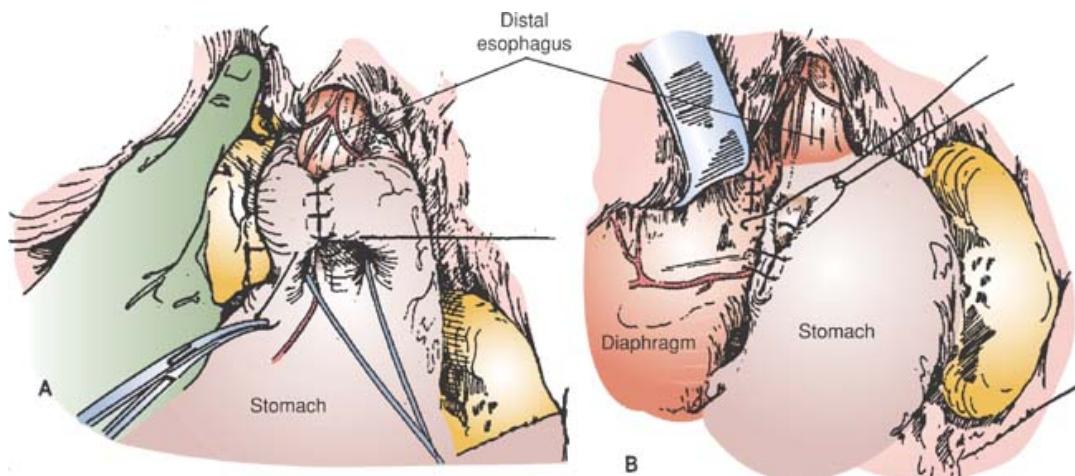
A. Nissen fundoplication may be performed via either the transabdominal or transthoracic approach; B. Hill repair is performed through the abdomen. (Reproduced with permission from Hardy JD: *Hardy's Textbook of Surgery*, 2nd edition. JB Lippincott, Philadelphia: 1988.)
